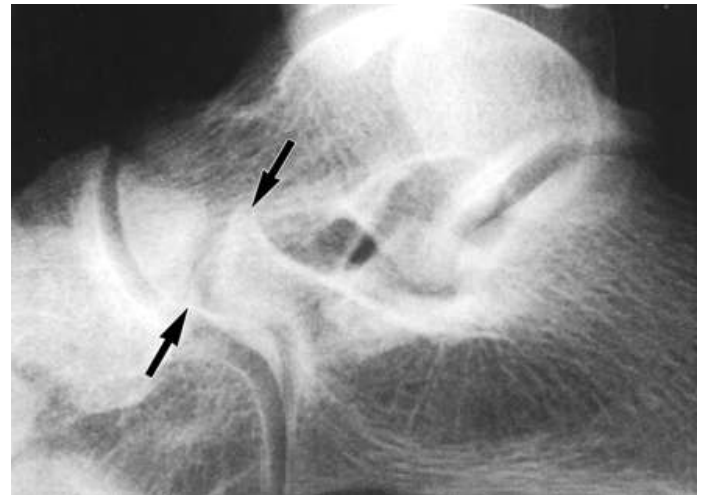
A lateral radiograph used to evaluate a calcaneo-navicular coalition of a 26-year-old woman. Shown above is that of the "anteater" sign. The anterior process of calcaneus (between arrows) is enlarged and elongated and has blunt tip like anteater's snout. This is one of the hallmarks in identifying the coalition.
